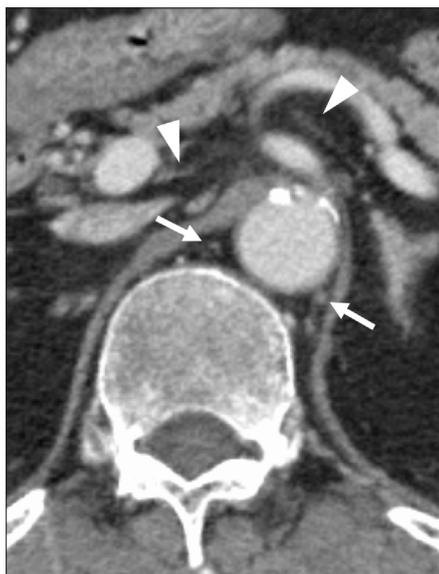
Axial CT image shows normal splanchnic and celiac ganglions. The splanchnic nerve is located in the retrocrural space, which is a narrow area surrounded by the crura of the diaphragm, vertebral bodies, and aorta (*arrows*). However, the celiac plexus is located over the anterolateral surface of the aorta and around the origin of the celiac trunk (*arrowheads*).
